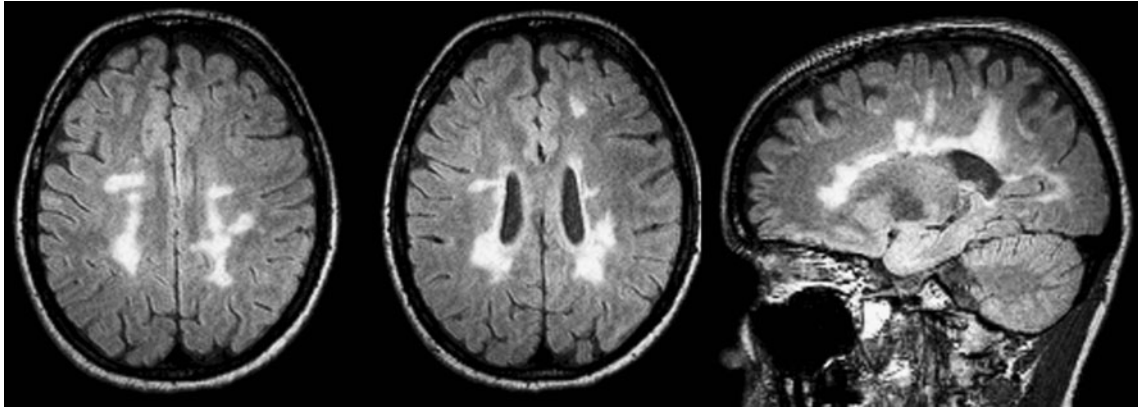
Axial and sagittal T2-FLAIR images of a 31-year-old man with MS demonstrate typical confluent periventricular lesions in the white matter
